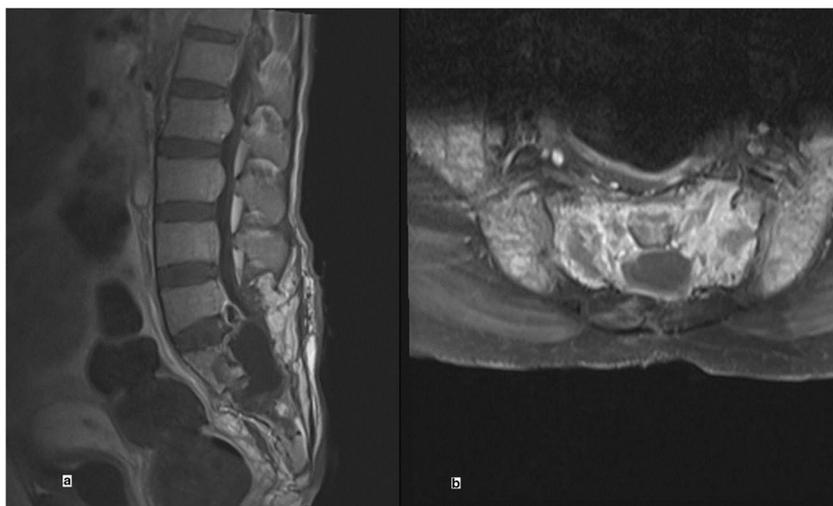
a View of the mass place in the sagittal sectioned MR image with contrast after the 18th month of surgery. b View of the mass place in the axial sectioned MR image with contrast after the 18th month of surgery
